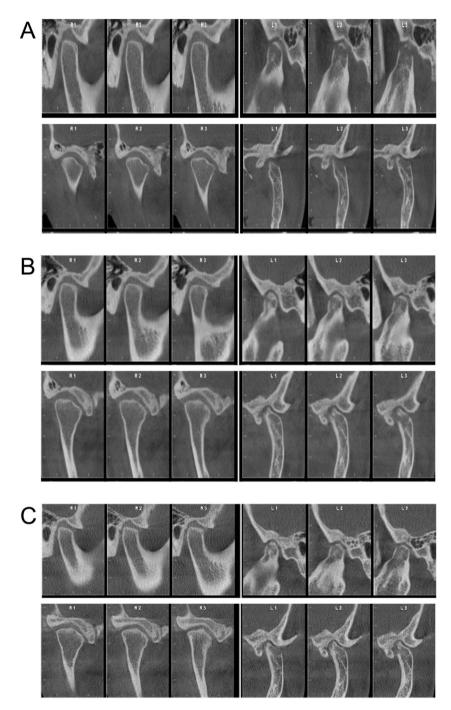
(A) Bilateral CBCT image of the TMJ immediately after treatment. The newly positioned fossa formed a remarkable curve, and there was an increase in bone mass. (B) Bilateral CBCT image of the TMJ 2 years after treatment. (C) Bilateral CBCT image of the TMJ 4 years after treatment. Long-term stability of TMJ self-remodeling was confirmed.
